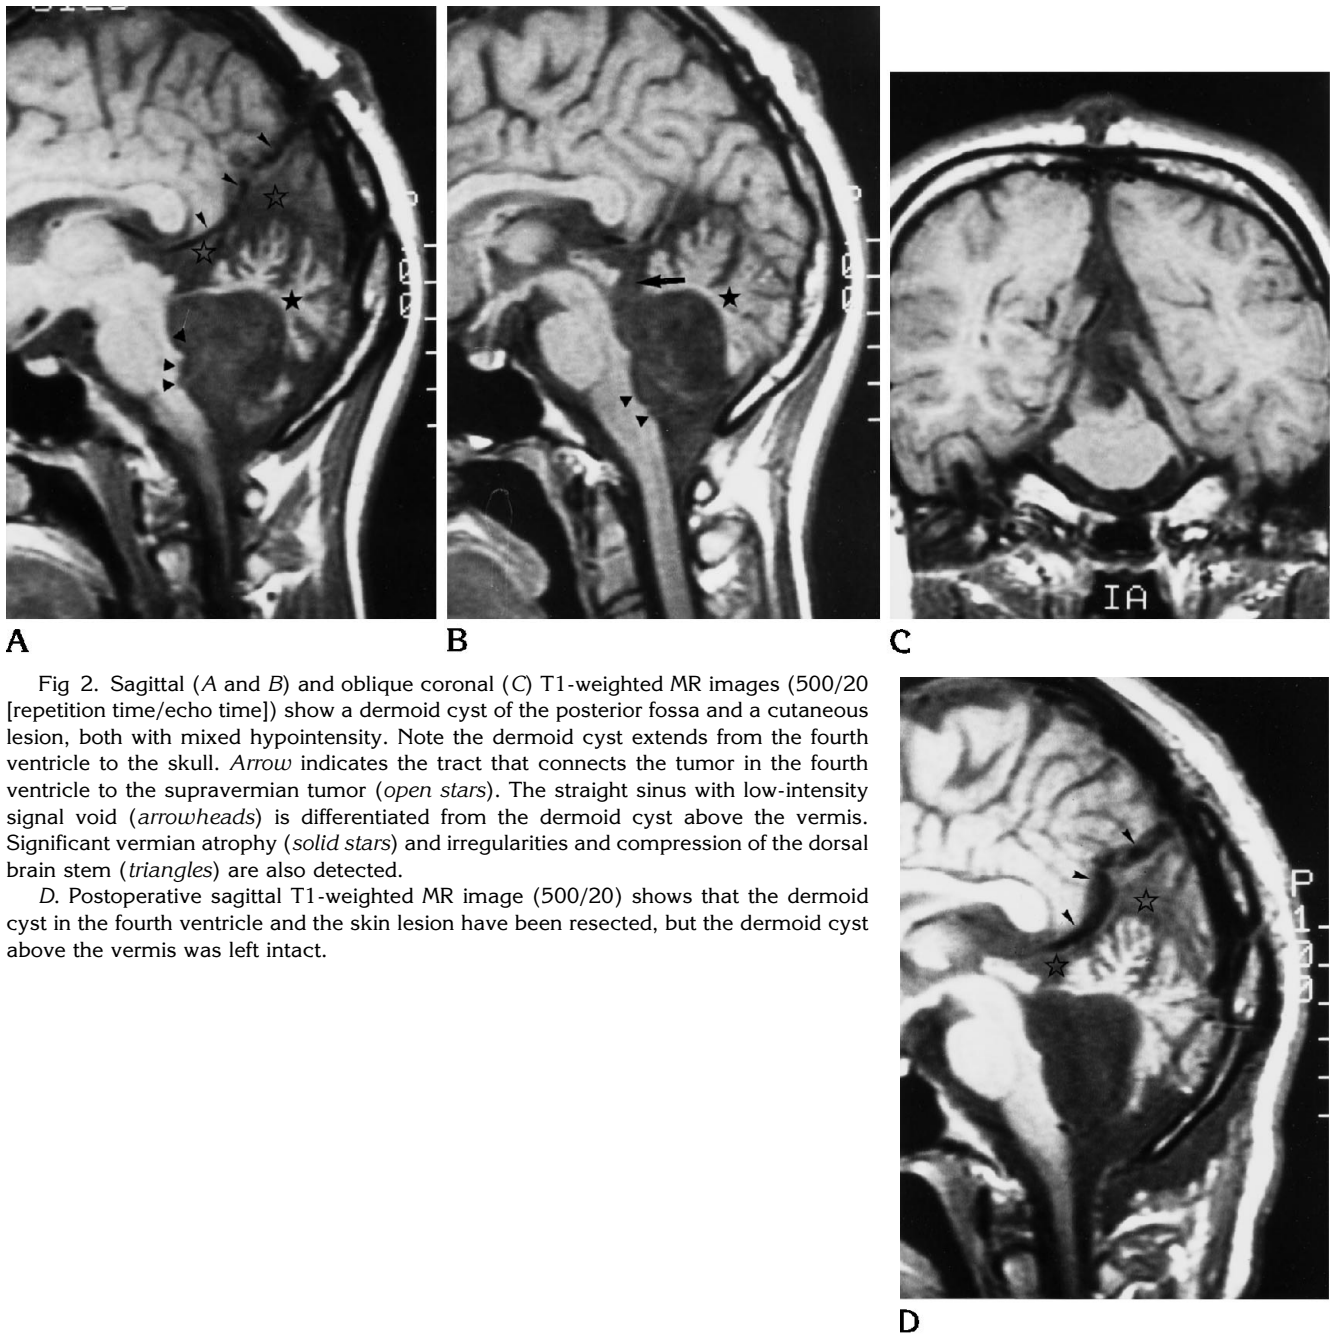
Sagittal (A and B) and oblique coronal (C) T1-weighted MR images (500/20 [repetition time/echo time]) show a dermoid cyst of the posterior fossa and a cutaneous lesion, both with mixed hypointensity. Note the dermoid cyst extends from the fourth ventricle to the skull. Arrow indicates the tract that connects the tumor in the fourth ventricle to the supravermian tumor (*open stars*). The straight sinus with low-intensity signal void (*arrowheads*) is differentiated from the dermoid cyst above the vermis. Significant vermian atrophy (*solid stars*) and irregularities and compression of the dorsal brain stem (*triangles*) are also detected.
